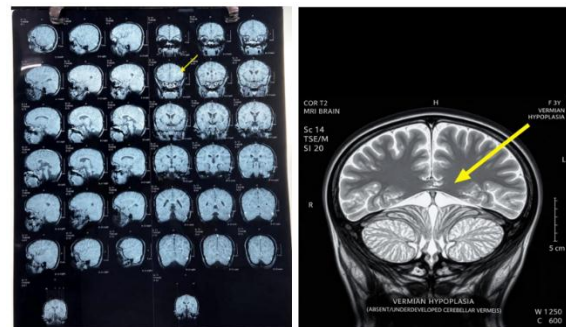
Magnetic resonance imaging of the brain showing vermian hypoplasia
